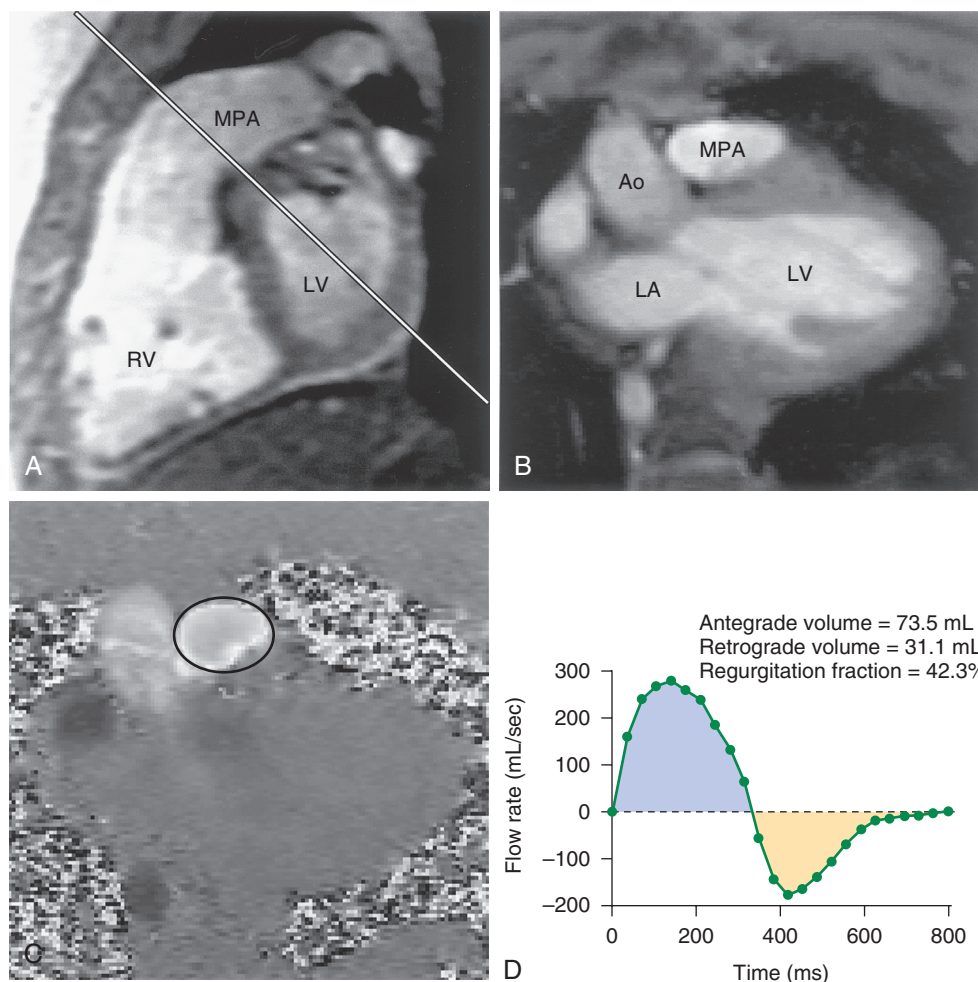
■ Quantitative assessment of pulmonary regurgitation by velocity-encoded cine magnetic resonance imaging (MRI) in a 26-year-old patient with repaired tetralogy of Fallot. A, An imaging plane is placed across the main pulmonary artery (MPA) (multiphase gradient echo cine MR). B, Magnitude image showing bright signal in the proximal MPA. C, The corresponding phase image contains the velocity and directional data. Using a computer workstation, a region of interest (*oval*) is placed around the MPA. D, The systolic flow-time integral (area under the curve above the baseline) yields the antegrade flow volume, and the diastolic flow-time integral (below the baseline) corresponds to the regurgitant flow volume. Regurgitation fraction is calculated as the ratio of retrograde (regurgitant volume) to antegrade volume. Ao, Aorta; LA, left atrium; LV, left ventricle; RV, right ventricle.
